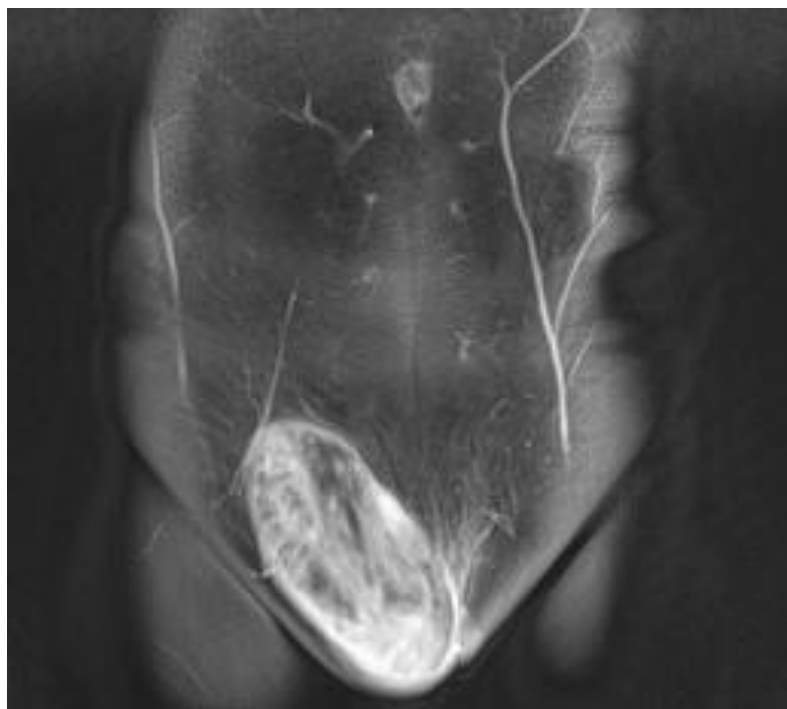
Coronal T1 VIBE with fat suppression MRI sequence demonstrates an oval, sharply contoured, heterointense lesion with solid and cystic components in the right inguinal area, showing moderate post-contrast enhancement of the solid component; the lesion measures 120 × 45 mm in the coronal plane
